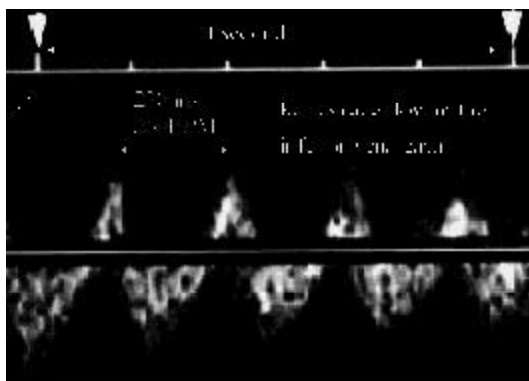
Supraventricular tachycardia with 1:1 atrioventricular conduction with the rate of 270 beats per minute (bpm) in a mildly hydropic fetus at 32 weeks of gestation. A, M-mode echocardiogram with simultaneous recording of atrial and ventricular contractions (small arrows). A small pericardial effusion is seen (large arrow). B, simultaneous Doppler interrogation of the left ventricular inflow and outflow tract showed synchronous atrial and ventricular activity. On the mitral valve tracing E wave is larger than the A wave; AO, aortic flow. C, Doppler probe in the inferior vena cava. A retrograde flow was observed. Transplacental treatment with digoxin was unsuccessful. Flecainide was added and partial control of arrhythmia was achieved with persistence of hydrops. A combination of digoxin and amiodarone converted the abnormal rhythm to sinus rhythm. Hydrops has disappeared but atrioventricular reentry tachycardia returned few hours after birth and was controlled with propranolol.
